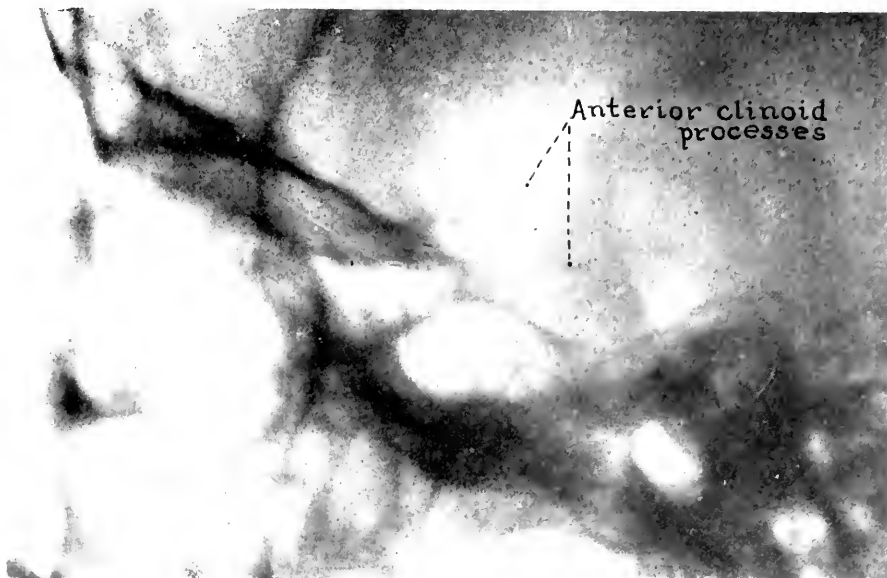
Case V. A badly centered X-ray plate showing thinned, elevated, and pointed anterior clinoid processes regarded at the time as uninforming (*cf.* Fig. 31).
